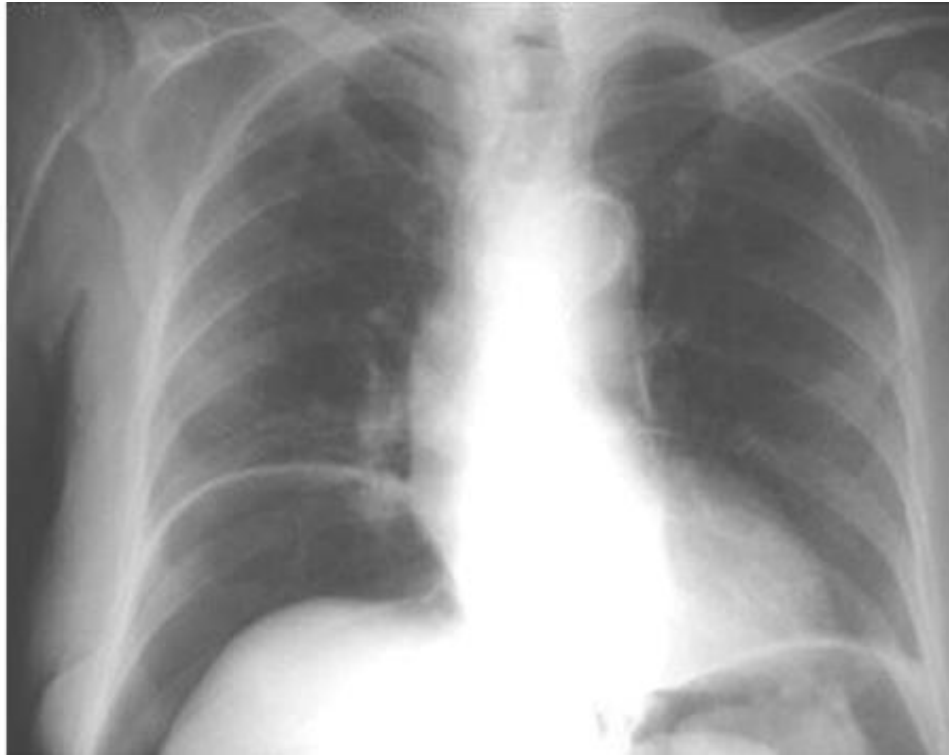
Radiograph showing free gas under diaphragm
